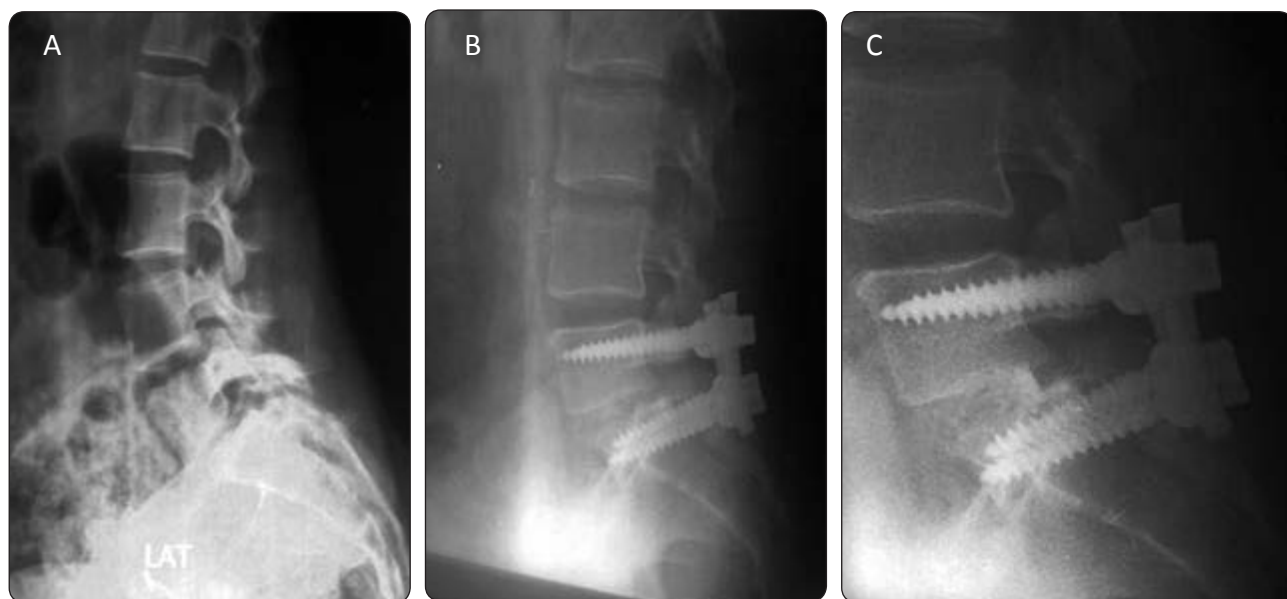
A: Plain X-ray lateral standing view of case with grade II isthmic spondylolisthesis of L5-S1 junction. Preoperative estimated values of lumbar lordosis, sacral tilt and slip angles were, 35, 32 and 11 degrees. B: Postoperative X-ray lateral view with reconstructed values 29, 24, 10 degrees. C: Plain lateral view showed intrbody bridging bone masses after 12-months postoperatively.
